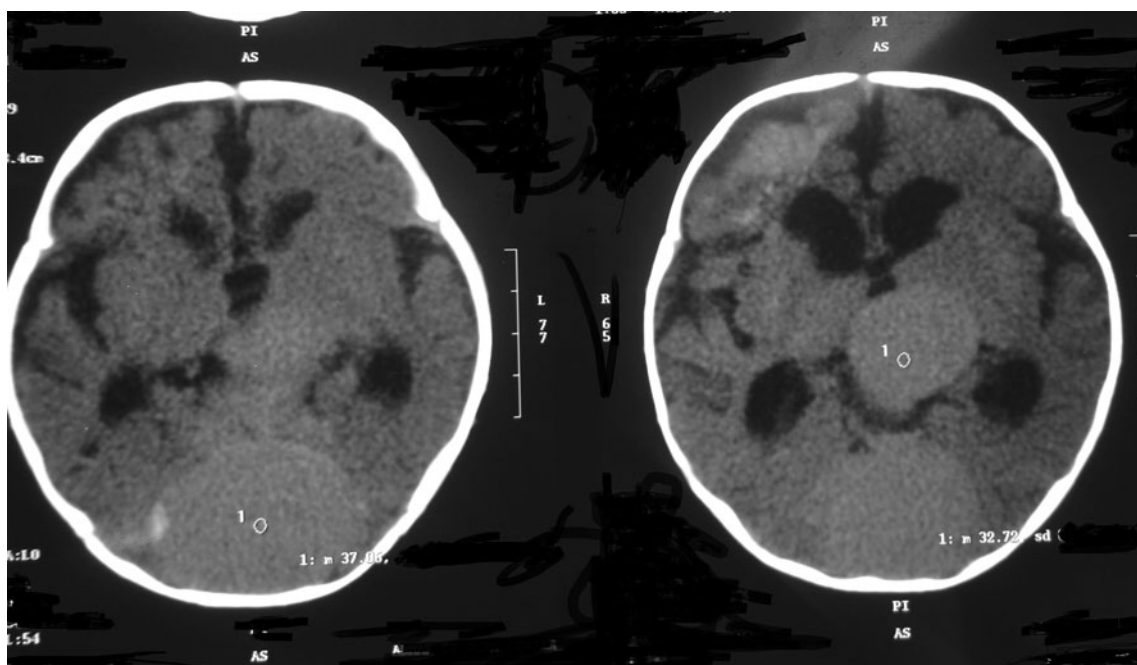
First brain computed tomography scan shows three ventricular hydrocephalus and severely dilated vein of Galen and torcula herophili
